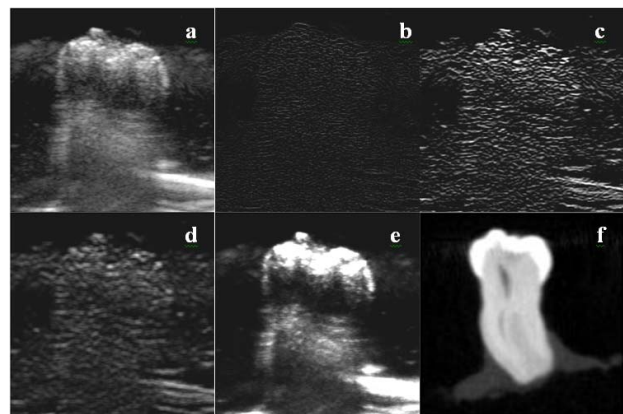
(a) Raw ultrasound image. (b) Laplacian kernel output of (a). (c) Sobel output of (a), and then, (d) smoothed with a 5x5 averaging kernel. (e) Sum of (b) and (d) multiplied by (a) after scaling. (f) CT image of the cross section corresponding to (a).
